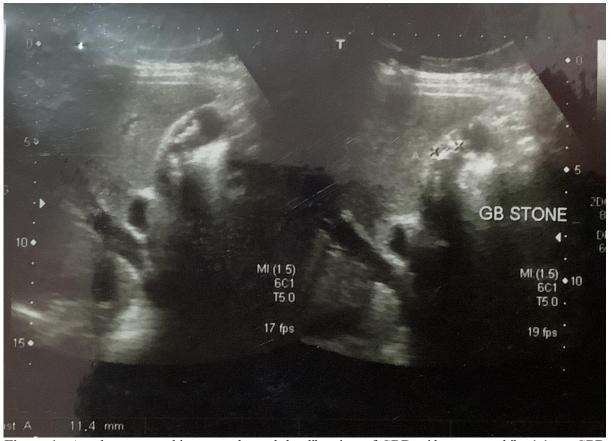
An ultrasonographic exam showed the dilatation of CBD with a non-mobile 1.1 cm CBD stone
